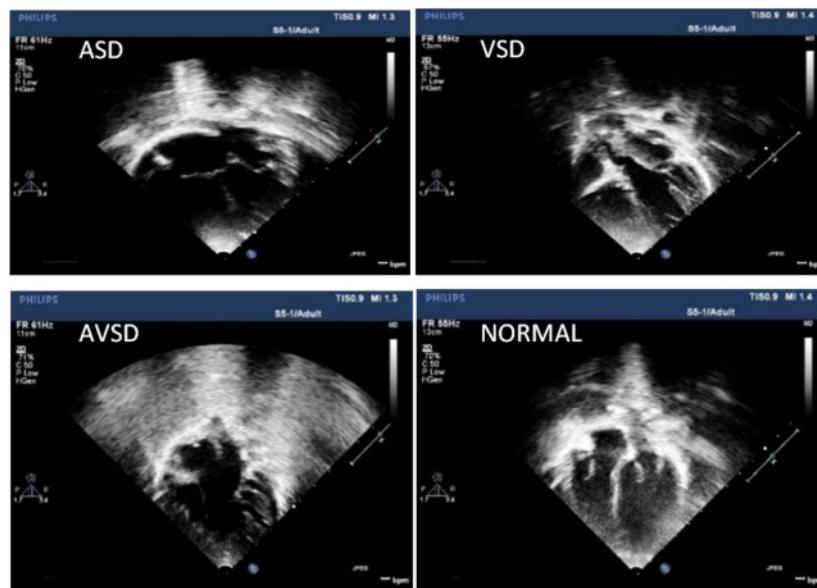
Sample of raw data for ASD, VSD, AVSD, and normal heart from apical 4 and 5 chamber view in 2-D echocardiogram. Data source of RSMH medical records, November 7, 2019.
